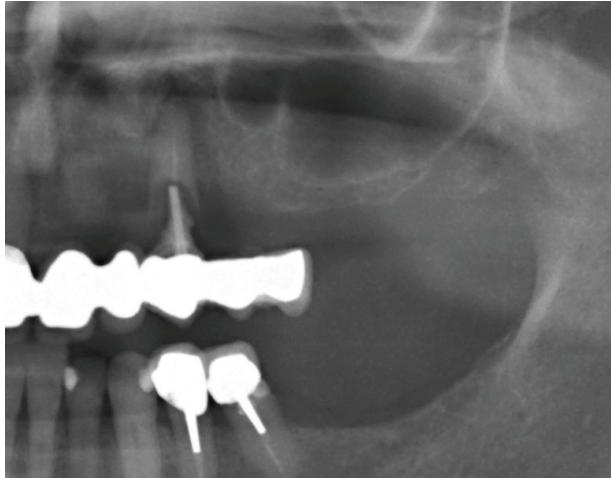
A fragment of preoperative OPG, patient V, 59-year-old. Absence of teeth 21, 22, 24, 25, 26, 27, 28. Periapical pathology of tooth #23.
